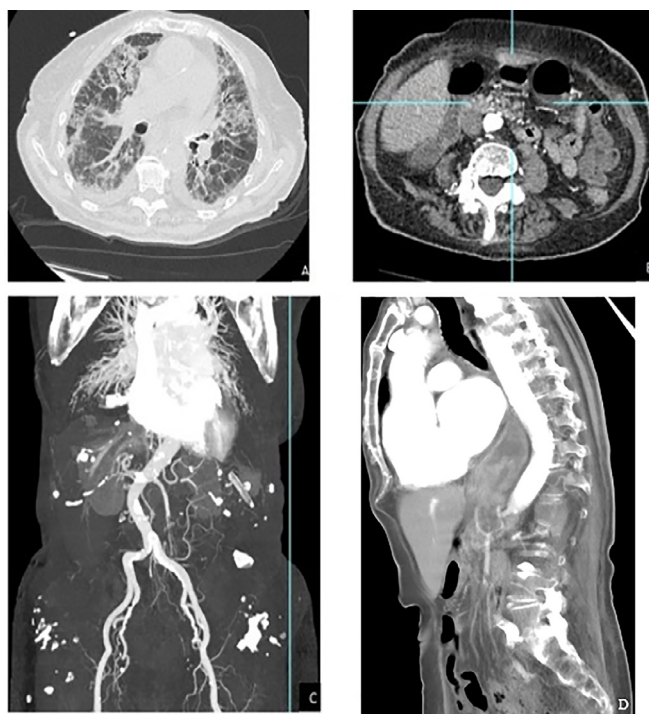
CT scan demonstrates bilateral opacities localized in peripheral and central parts of the lung, with prevalence of ground-glass pattern (a). Small bowel dilatation containing air-fluid levels (b). Superior mesenteric artery thrombotic occlusion and splenic infarction (c), and relative sagittal view (d).
